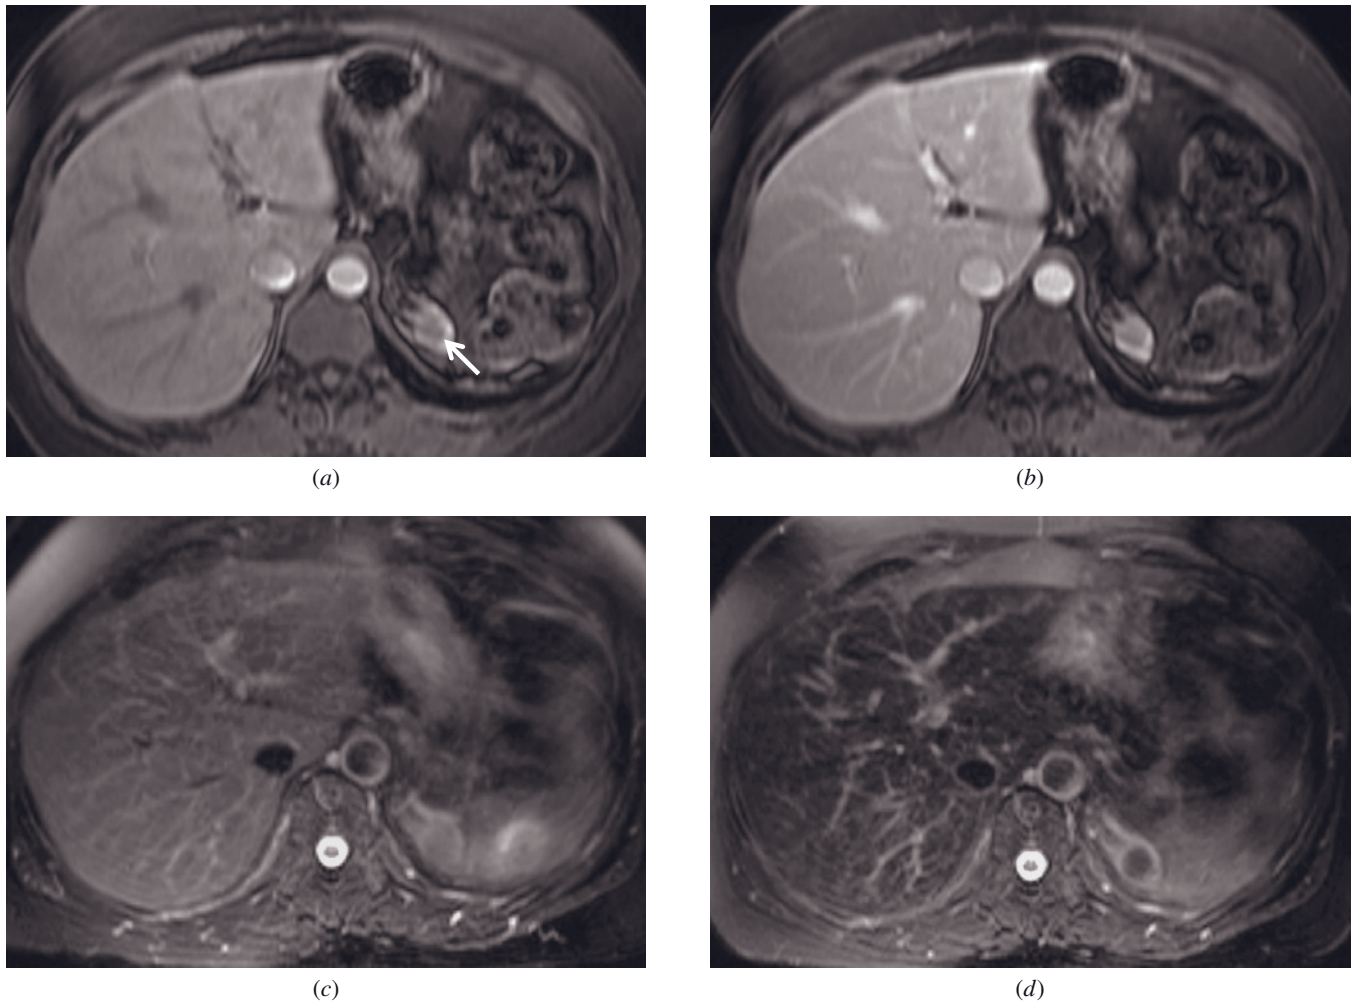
Differentiation of pancreatic cancer from intrapancreatic splenule. T1-weighted postgadolinium fat-suppressed hepatic arterial dominant phase (a) and hepatic venous phase (b) 3D-GE images and T2-weighted pre-superparamagnetic iron oxide (SPIO) (c) and post-SPIO (d) images demonstrate a lesion in the pancreatic tail in a patient with splenectomy. The pancreatic tail is located in the splenic fossa due to the operation. The lesion shows low signal on postgadolinium T1-weighted images. The differential diagnosis includes pancreatic cancer based on the findings of postgadolinium imaging. However, the lesion shows lower signal after SPIO administration. Therefore, the diagnosis is consistent with intrapancreatic splenule.
